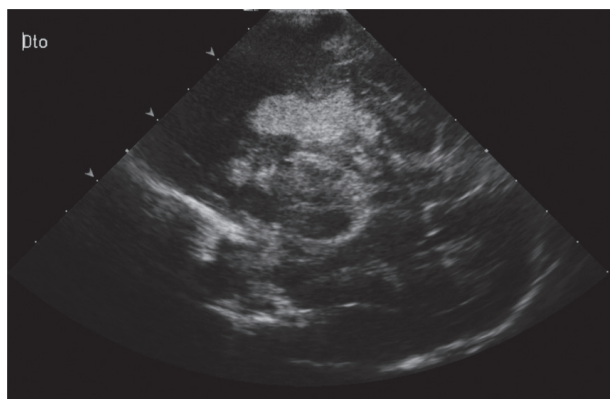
Cerebral ultrasound showing extensive heterogeneous peri-intraventricular hemorrhage.
